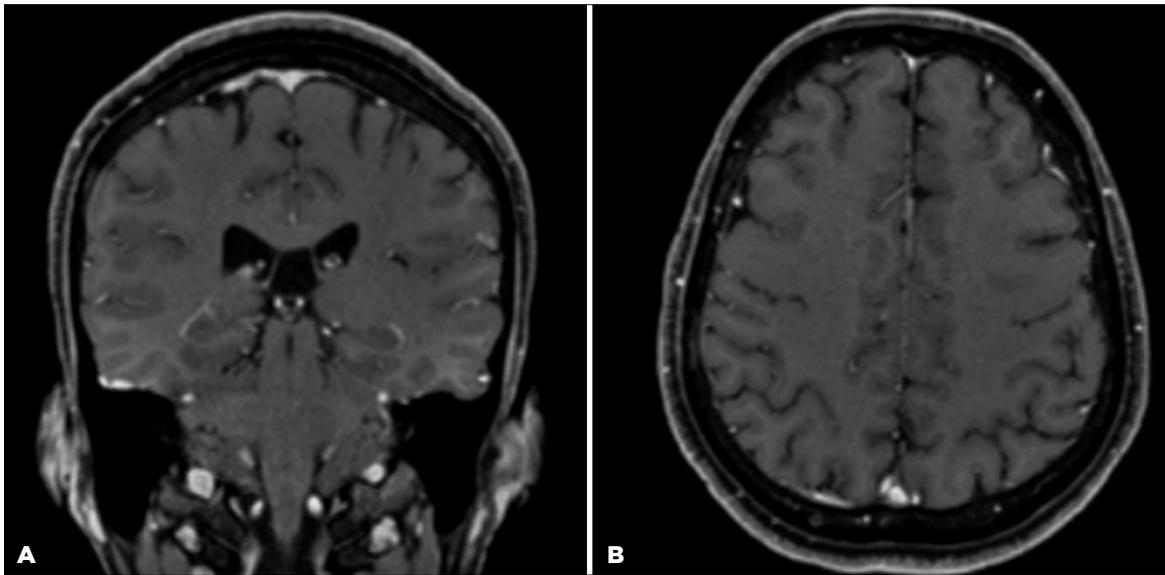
(A) Magnetic resonance images of the coronal and (B) axial frames after treatment.
